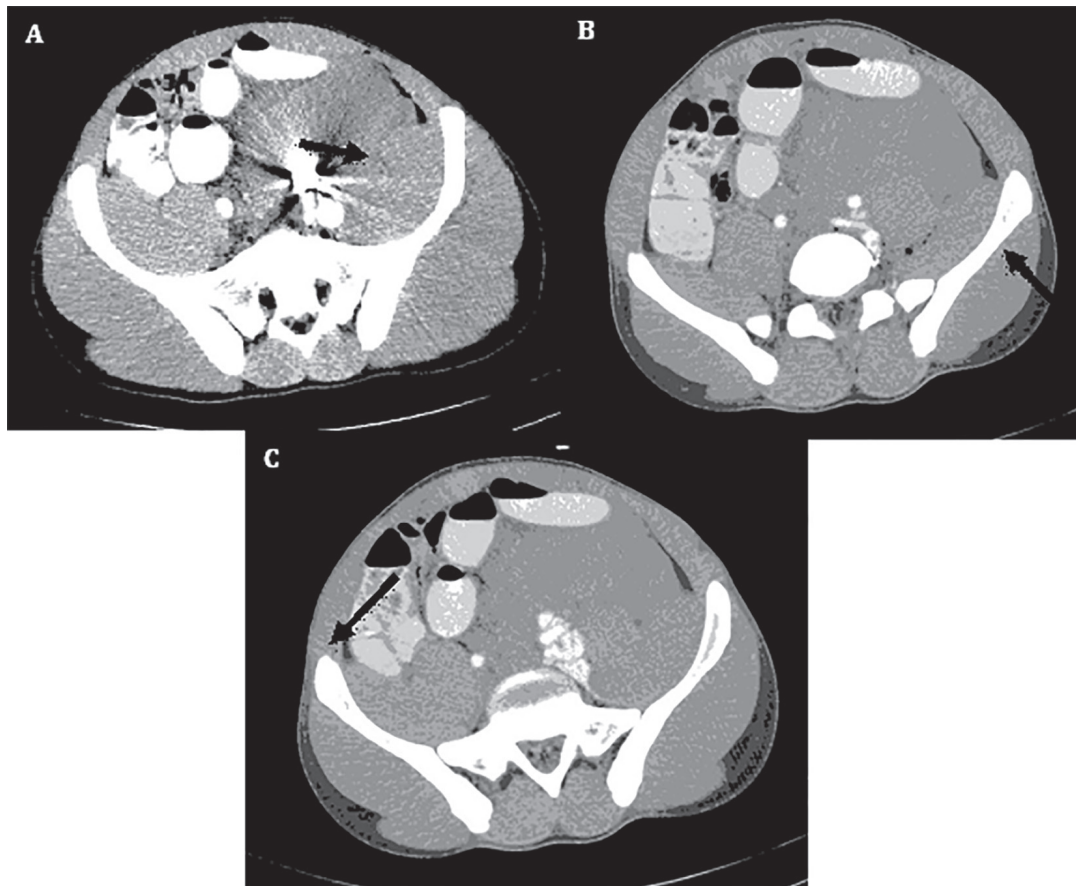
Axial abdominopelvic CT-scan of the patient demonstrating the bullet fragment adjacent to the left common iliac artery (A); large left retroperitoneal hematoma (B); extravasation of intravenous contrast from injured left iliac artery suggestive of arteriovenous fistula formation to the common left iliac vein.
